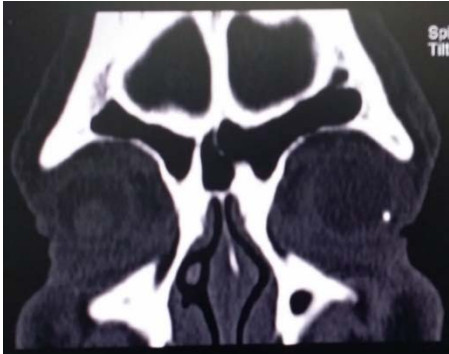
CT orbit axial cut showing radio-opaque IOFB in infero-lateral and posterior aspect of left eye globe.
